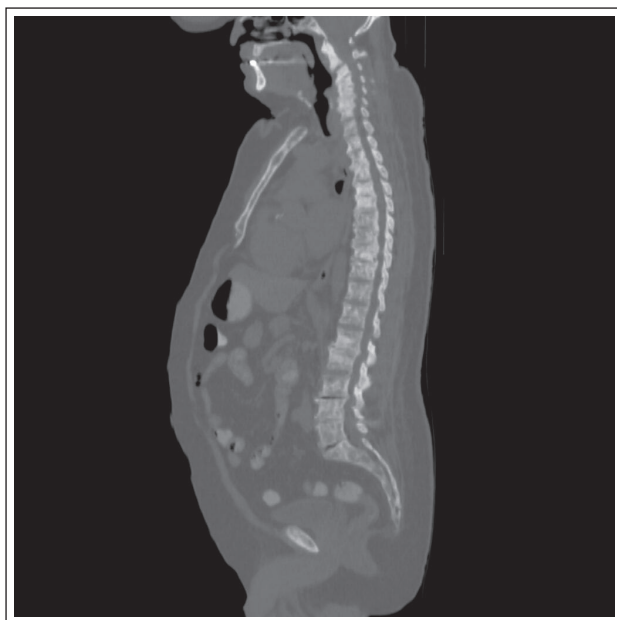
The widespread sclerotic bone lesions are shown in the low-density computerized tomography part of PET/CT.
